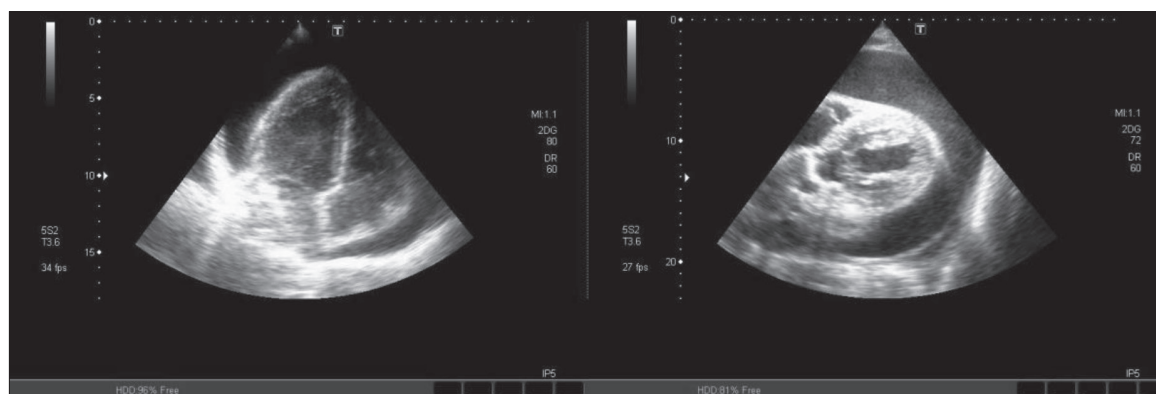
Echocardiographic findings in threatening cardiac tamponade; “Swinging heart” sign, where the heart moves like a pendulum within a massive pericardial effusion
